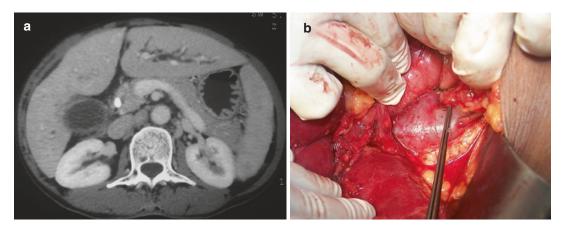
Aortocaval lymph node (a) on CT (b) at operation
